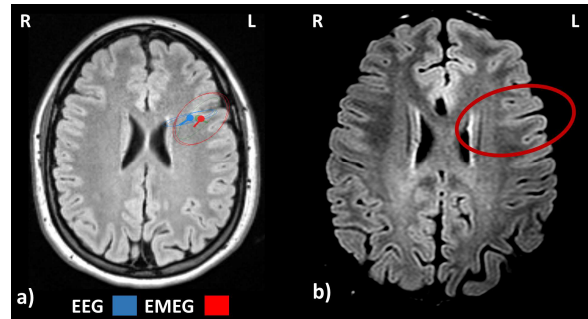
a) The estimated sources with estimated extent (spread sphere) from EEG and EMEG at -10.83 ms was located in an area where b) the patient's 3D-FLAIR MRI was also suspicious with regard to an FCD (see the blurred cortical area in the middle of the red ellipsoid). The letters, L and R denote 'left' and 'right' respectively.
